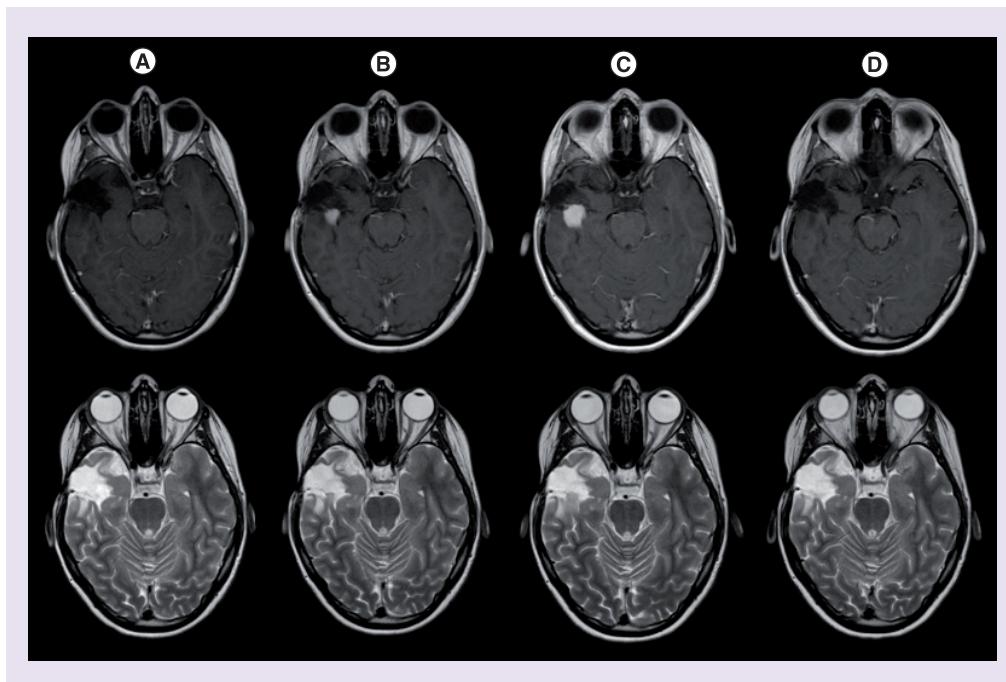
Serial MRI. Above: T1 sequences with Gadolinium, below: T2 sequences. (A) Complete radiological response following 18 months of dabrafenib therapy. (B) New enhancing nodule after 2 months of stopping dabrafenib. (C) Progressing nodule after 2 months. (D) Radiological response after 3 months of therapy with dabrafenib and trametinib.
